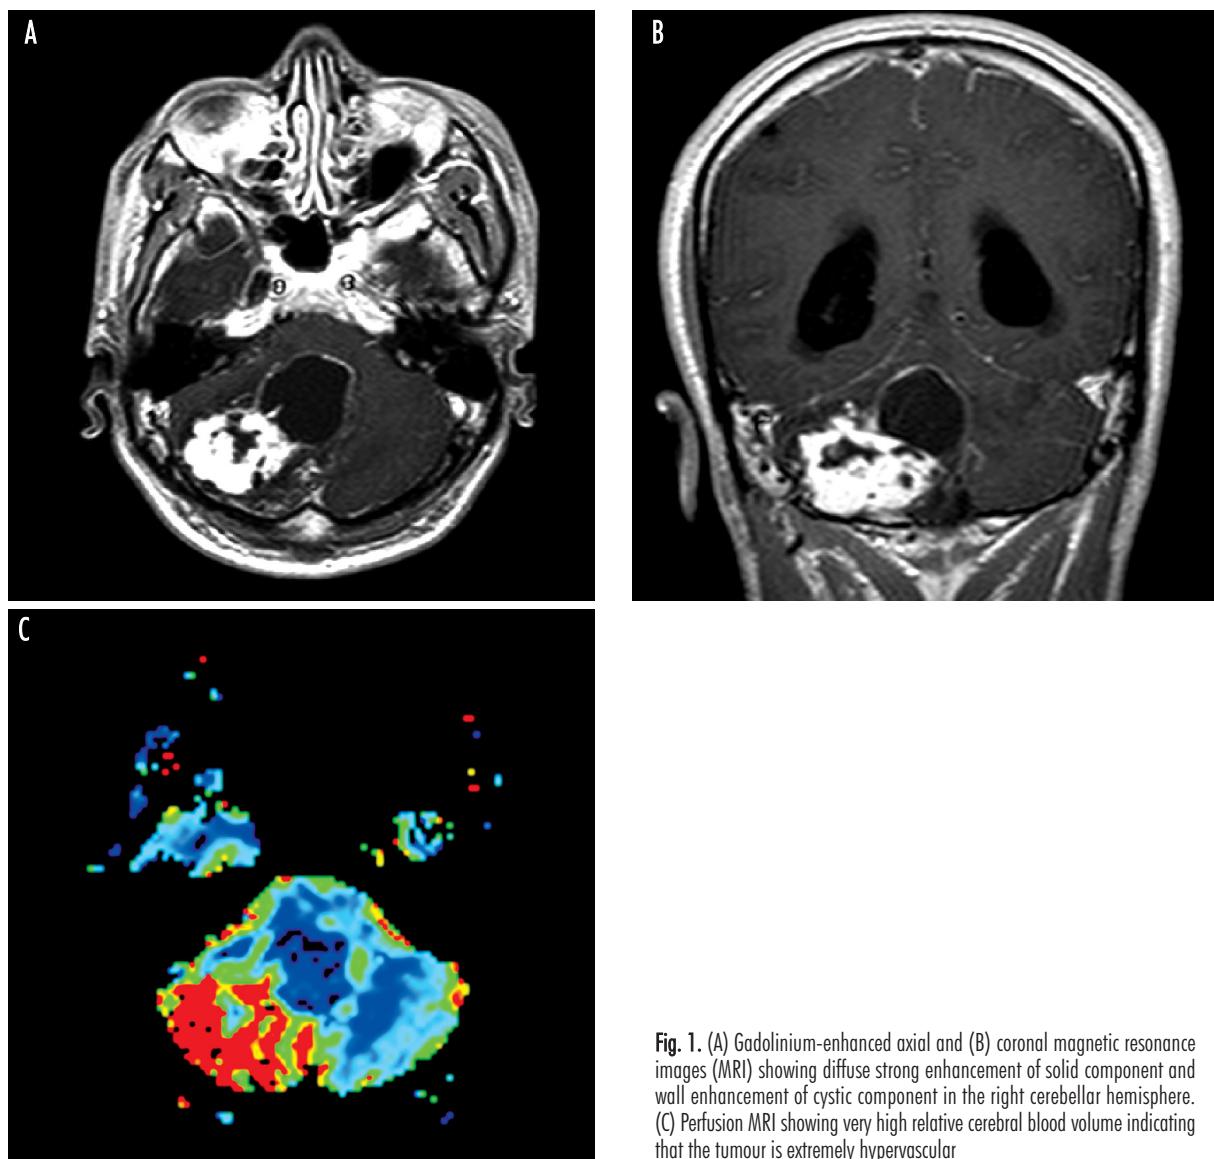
(A) Gadolinium-enhanced axial and (B) coronal magnetic resonance images (MRI) showing diffuse strong enhancement of solid component and wall enhancement of cystic component in the right cerebellar hemisphere. (C) Perfusion MRI showing very high relative cerebral blood volume indicating that the tumour is extremely hypervascular
